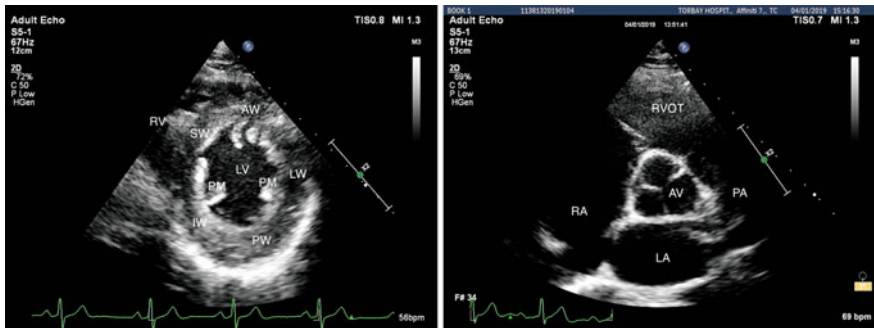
Parasternal short axis view at papillary muscle level (a) and aortic valve level (b) showing right ventricle (RV), left ventricle (LV), papillary muscles (PM), septal wall (SW), anterior wall (AW), lateral wall (LW), posterior wall (PW) and inferior wall (IW), aortic valve (AV), right atrium (RA), left atrium (LA), right ventricular outflow track (RVOT) and pulmonary artery (PA)
